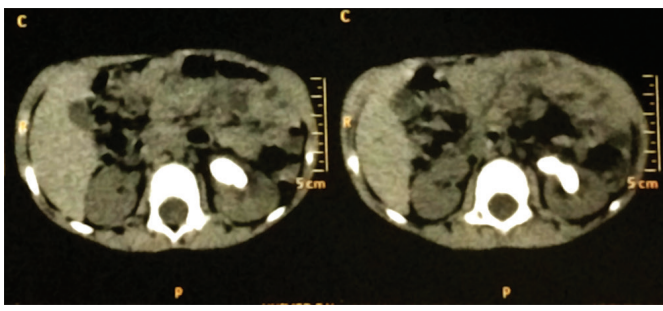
CT scan of abdomen and pelvis showing hyperintense mass in the left kidney
